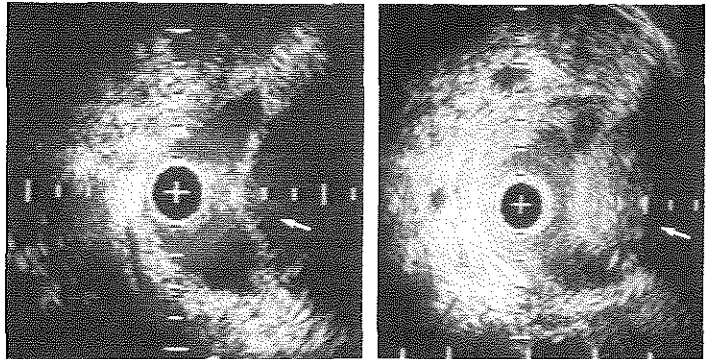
Intravascular sonogram after angioplasty shows moderate extrinsic compression, with arterial wall partially compressed into lumen (arrow).
